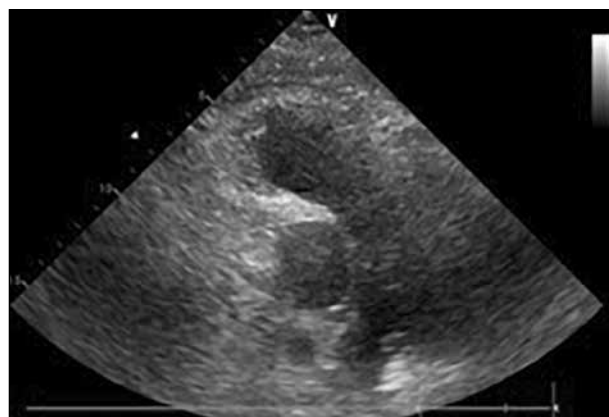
Parasternal short axis view of the pulmonary artery showing the complete resolution of the thrombus on the bifurcation of the pulmonary artery.
